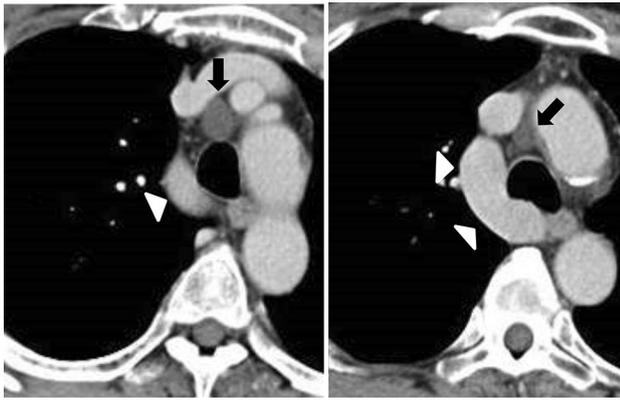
Computed tomography (CT) showing the mediastinal tumor (arrow) with a diameter of 20 mm located at the pretracheal region close to the dilated azygos vein (arrowhead) with a diameter of 25 mm
